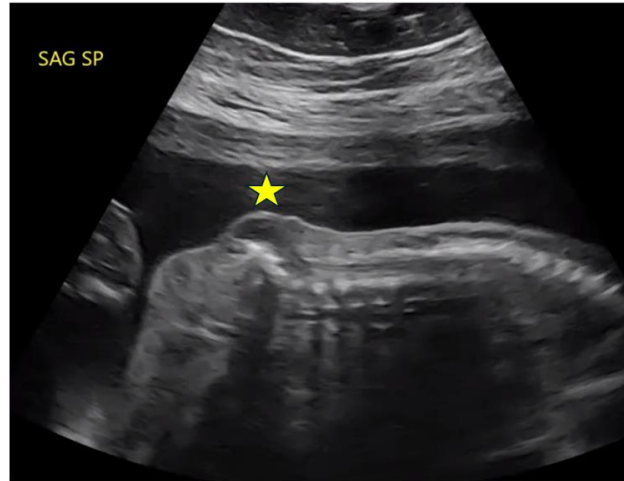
Transabdominal ultrasound at 24 3/7 weeks EGA showing sagittal view of thoracic and lumbar spine with an MMC noted at the caudal aspect of the image (yellow star).
